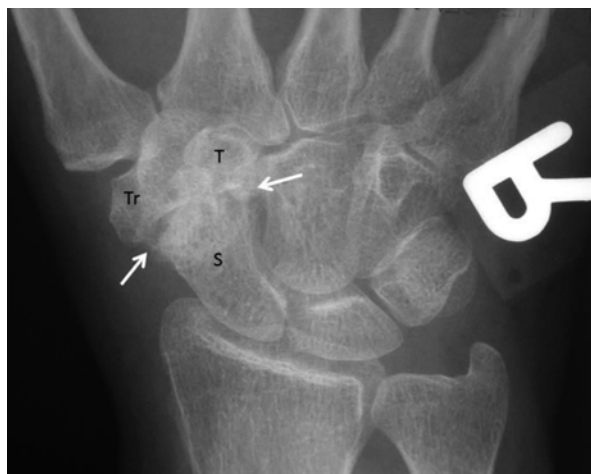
STT joint OA (arrows) seen on a radiograph of a right wrist between the scaphoid (S), the trapezium (Tr), and the trapezoid (T) carpal bones. The STT joint is the second most common site of OA in the wrist, this condition has variable symptomatology
